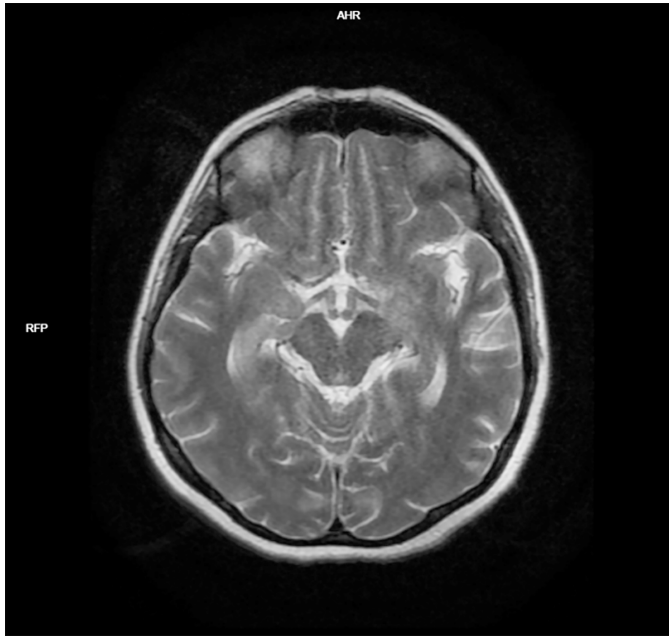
Axial T2-weighted MRI taken with a 1.5-T scanner, showing hyperintensity in the right and left medial temporal lobes, consistent with neurosarcoidosis
